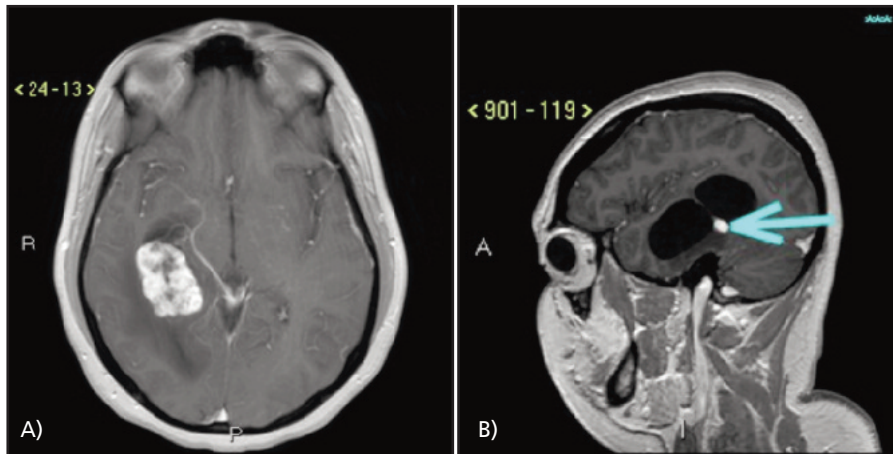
A) Magnetic Resonance Imaging (MRI) - axial gadolinium shows heterogenous, hyperintense, cauliflower appearance. B) MRI - sagittal T1 with gadolinium showing a hyperdense nodule.
